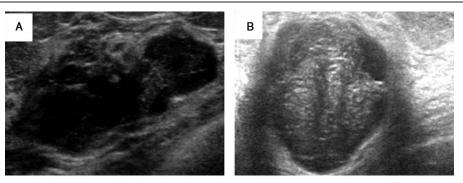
Ultrasound of younger sister's right breast showing a hypoechogenic mass with heterogeneous echotexture (A), and elder sister's left breast showing a hypoechogenic mass with internal anechoic area (B).
